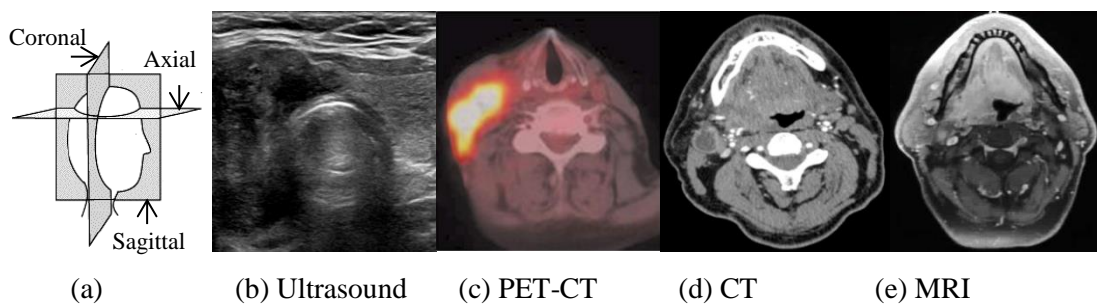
(a) anatomical planes (sagittal, coronal and axial) used to obtain medical images; (b)–(e) different imaging modalities (Ultrasound, PET-CT, CT and MRI) in axial plane used in diagnosis, staging and treatment of head and neck cancers. ((b), (c), (d) and (e): Courtesy of The Beatson West of Scotland Cancer Centre, Glasgow)
